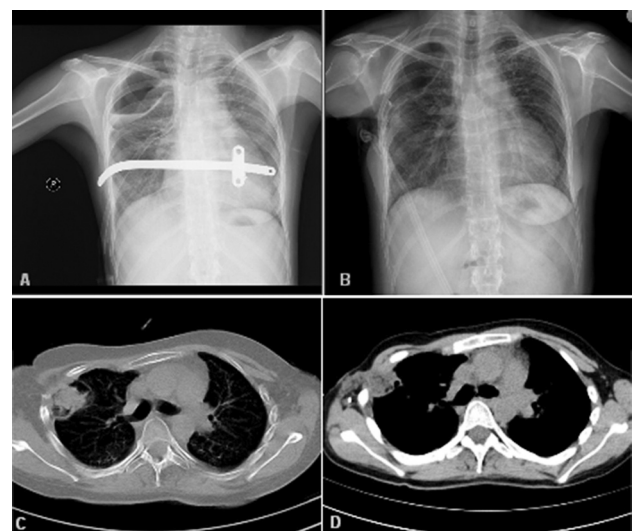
(A) Empty space with non-expanded lung. (B) Post Eloesser flap with vacuum-assisted closure device. (C) and (D) Computed tomographic scans showing vacuum-assisted closure dressing and latissimus dorsi, respectively, in the cavity.
